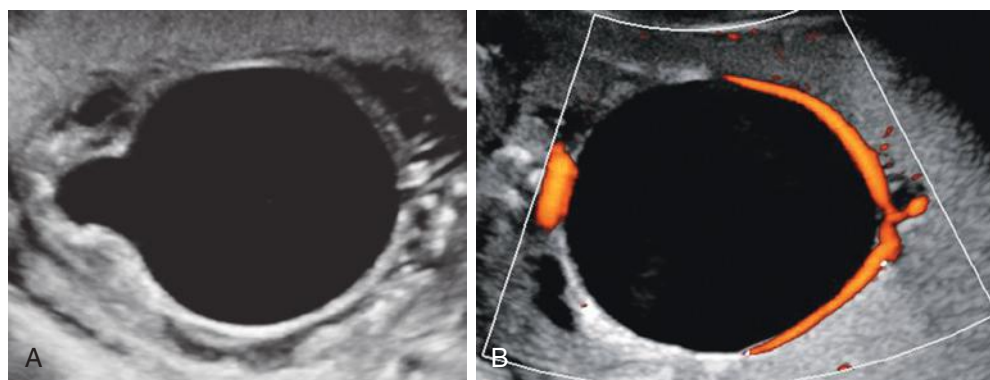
Posterior urethral valves. A, Enlarged bladder with classic keyhole appearance. B, Confirmation that this large fluid-filled structure represents the bladder by demonstration of umbilical arteries using color flow Doppler sonography.
